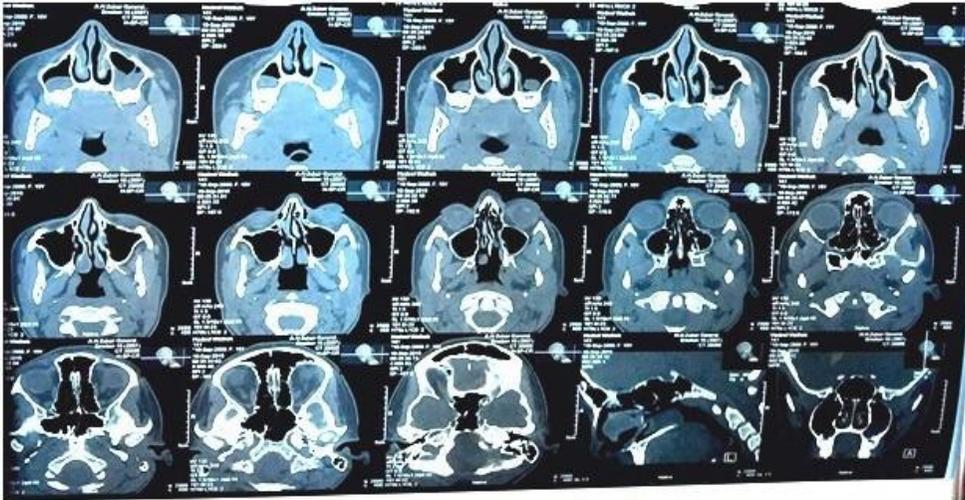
CT scan of maxillary sinuses.
